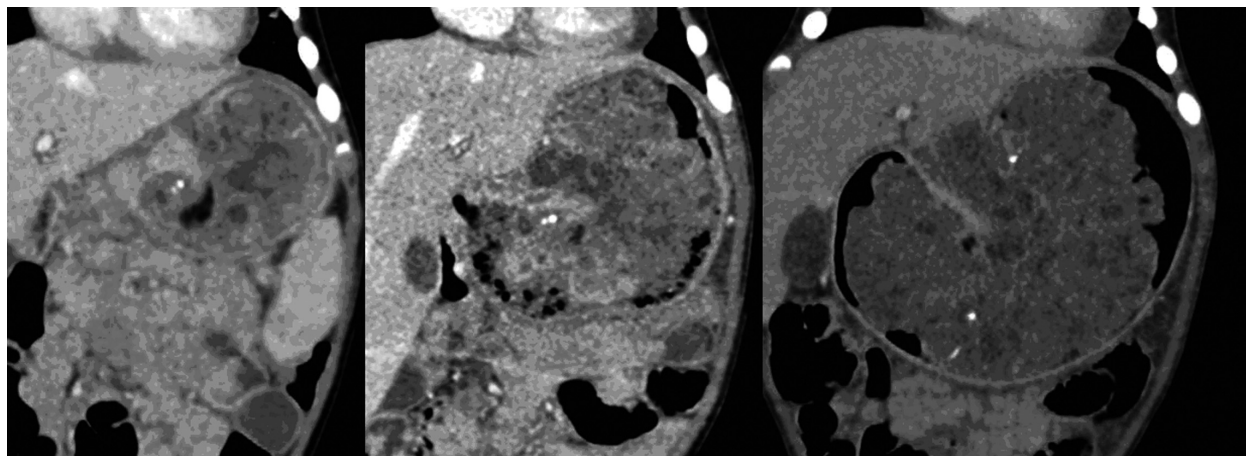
Coronal CT scan of the whole abdomen before, during, and after chemotherapy shows markedly increased size of the mass within 2 months with increased internal calcification and fat components.
